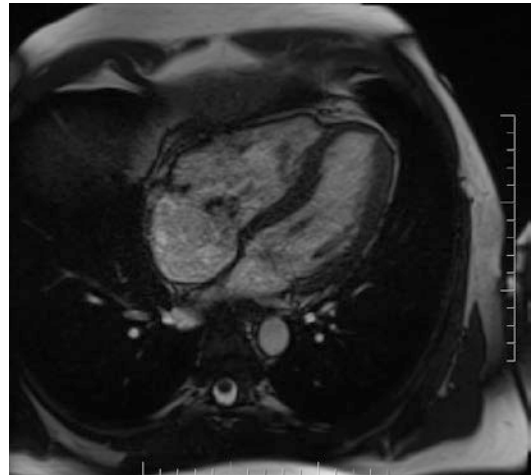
Cardiac magnetic resonance imaging of a tricuspid valve dysplasia and severe TR
